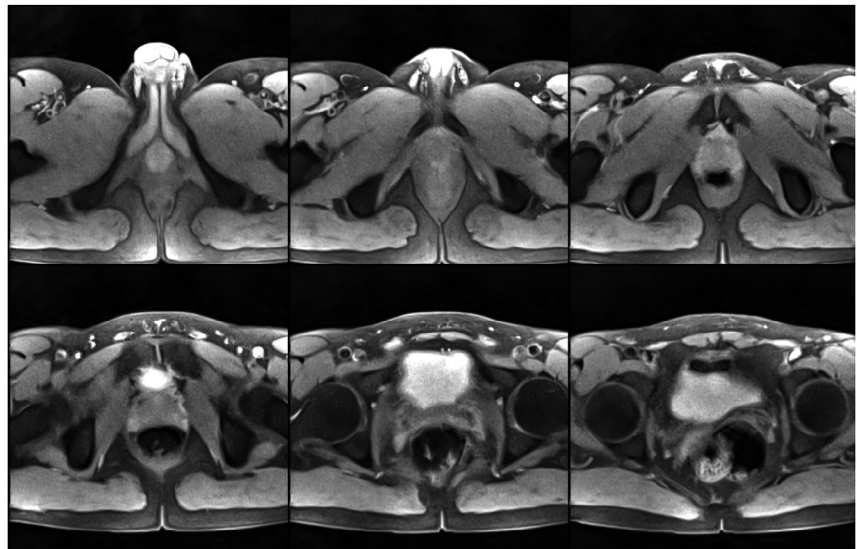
Selected fat-suppressed T_2/T_1 -weighted images (every 15th) of a 6.0-second real-time MRI acquisition covering the prostate (90-mm volume) of a healthy subject at 66.7 ms and $1.0 \times 1.0 \times 4.0 \text{ mm}^3$ resolution. For details, see Table 1
